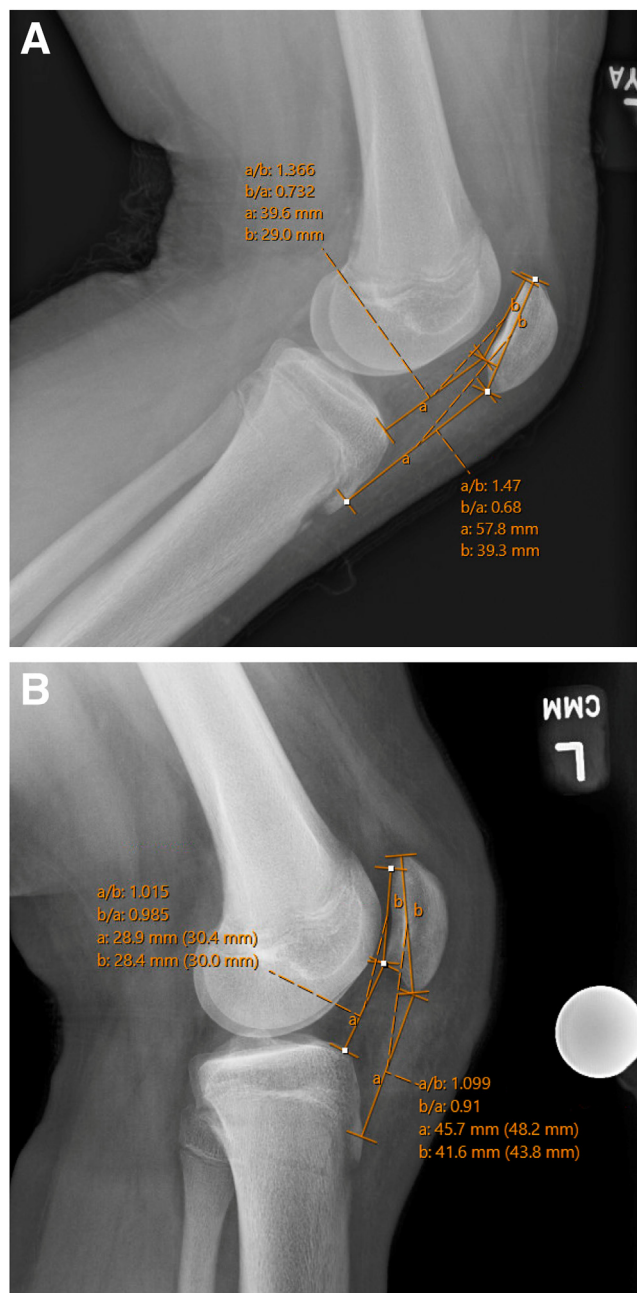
(A) Preoperative lateral view of left knee radiograph demonstrating patella alta with Caton-Deschamps index = 1.36 and Insall-Salvati ratio = 1.47. (B) Postoperative lateral view of left knee radiograph demonstrating improved patella height with Caton-Deschamps index = 1.02 and Insall-Salvati ratio = 1.10.
